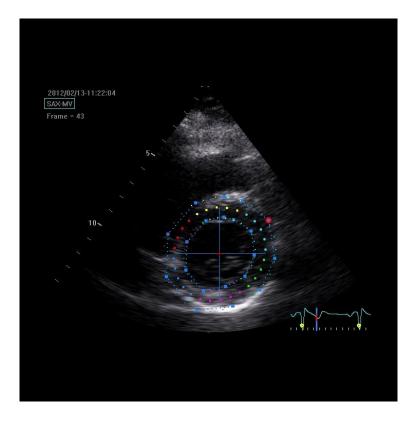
9 Region of interest for 2DST in basal parasternal short axis view.
